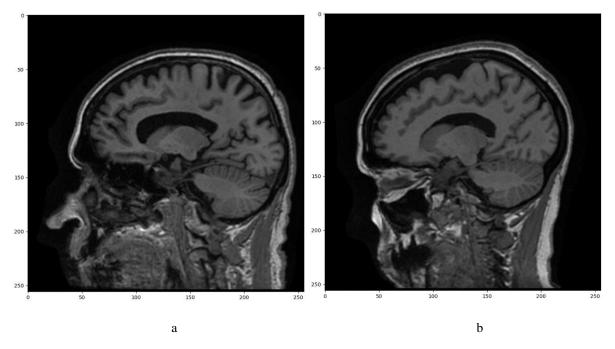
A sample of the dataset that was used in our study; a and b respectively represent the one T1 MRI (sagittal plane) slice with all of the brain tissues (skull, scalp, CSF, WM, and GM) of AD and MCI patients
